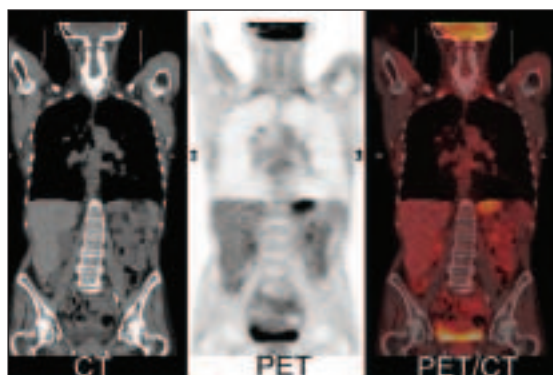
Limited whole-body F-18 FDG-PET/CT from the base of the skull to the upper thigh.
